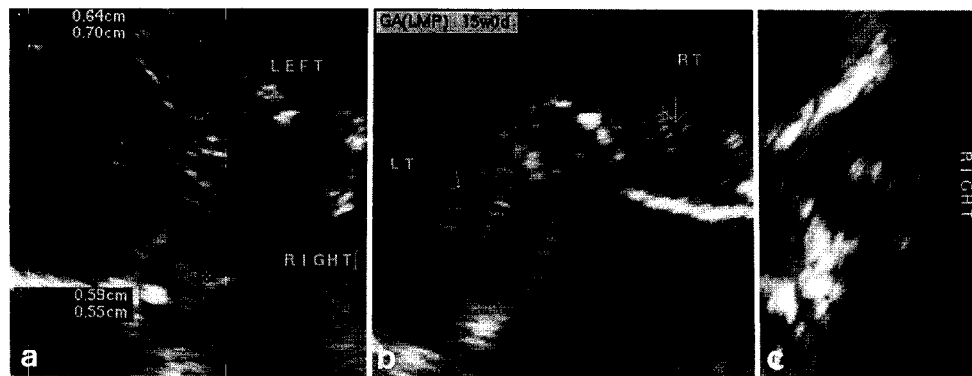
Transvaginal ultrasound image of the orbits and the lenses of the fetus at 15 weeks in the fourth pregnancy. (a) Asymmetry of the orbits; (b) sagittal views of both lenses; (c) coronal view of the right lens
